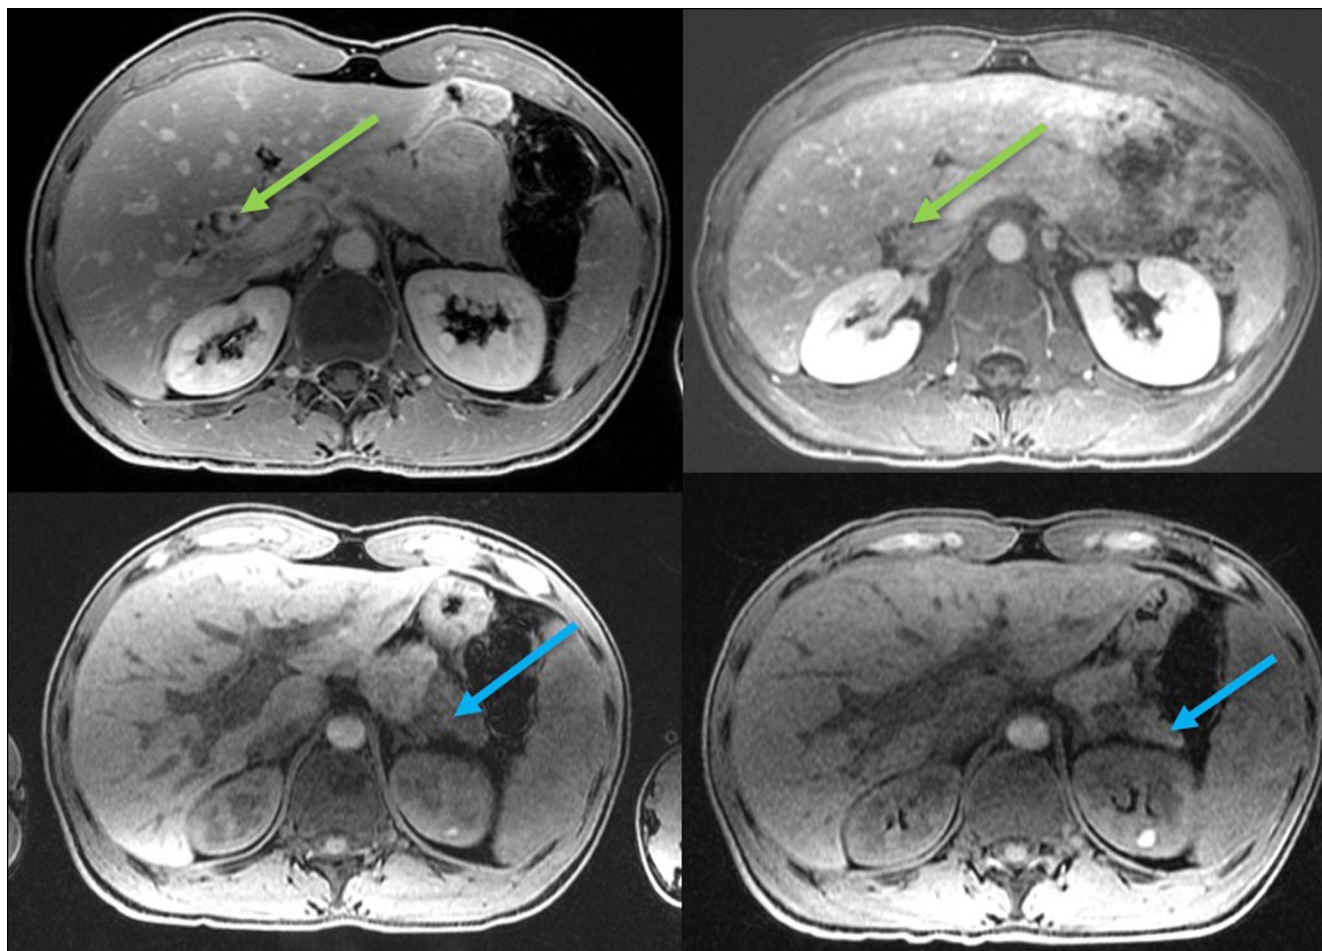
Left, top: Delayed postcontrast T1-weighted fat-suppressed image demonstrates marked peribiliary thickening and enhancement around the common hepatic duct (green arrow). Left, bottom: Axial T1-weighted precontrast fat-suppressed image reveals sharply demarcated abnormal hypointense T1 signal in the pancreatic tail (blue arrow). Right top: Delayed postcontrast T1-weighted fat-suppressed image obtained 6 months after initiation of steroids demonstrates resolution of peribiliary thickening and enhancement around the common hepatic duct (green arrow). Right, bottom: Delayed postcontrast T1-weighted fat-suppressed image obtained 6 months after initiation of steroids shows normalization of the T1 signal in the pancreatic tail (blue arrow).
